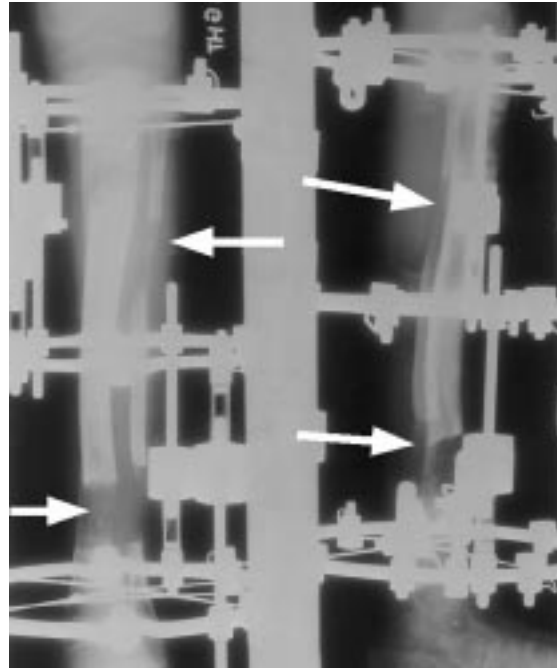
Radiographs of a child with congenital posteromedial bowing of the tibia and a projected limb-length discrepancy of 7 cm. Two-level corticotomies (bifocal lengthening) were performed to achieve lengthening at two sites in the tibia and thereby shorten the treatment time. Regenerate bone (arrows) is visible in the proximal and distal tibial lengthening sites.
